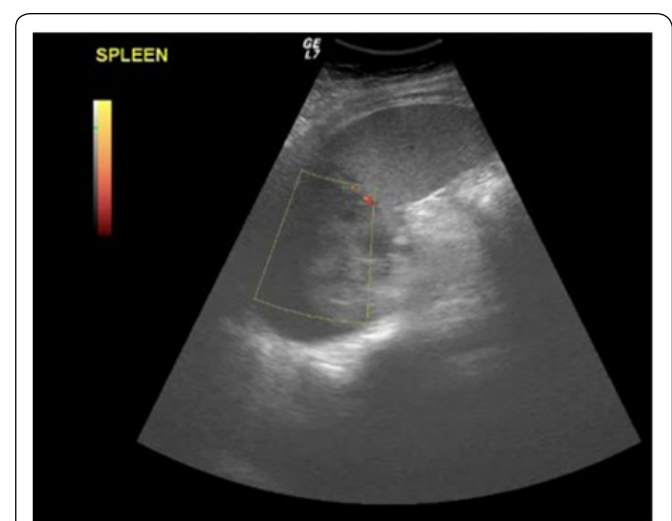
Splenic hematomas (color-Doppler).
